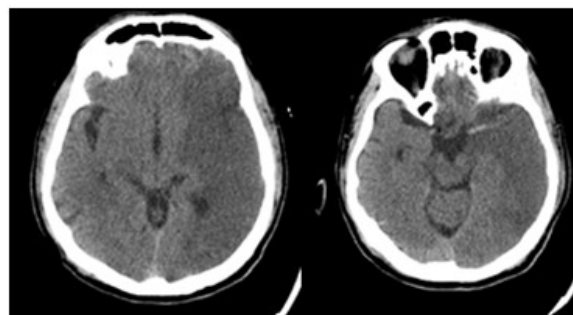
33 year old postpartum women with dense right hemiplegia, non contrast CT shows hypodense are in left fronto-parieto-temporal lobe with left dense MCA sign-Suggestive of left MCA infarct.
